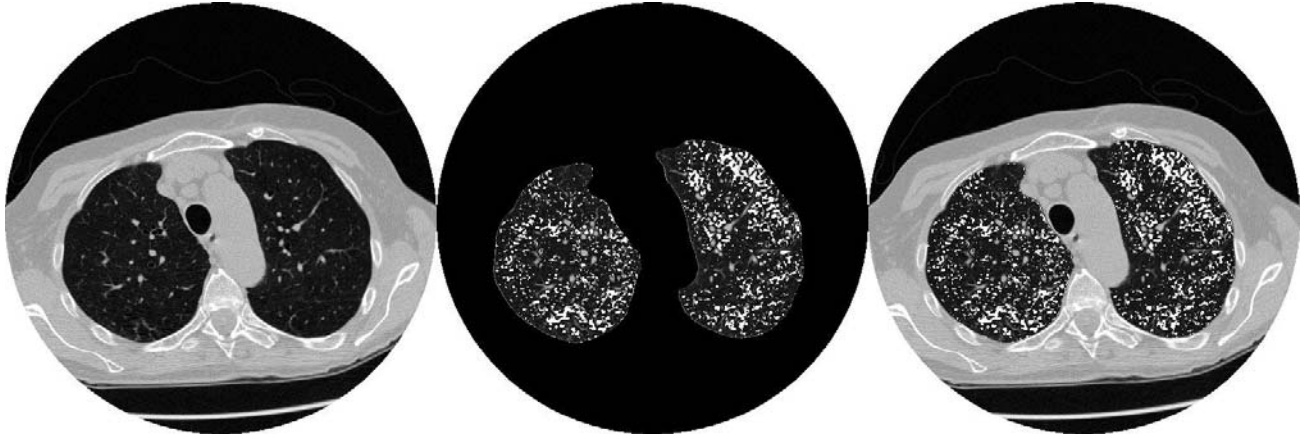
Sample emphysema index computed at -910 HU from a whole lung CT scan. Left: Standard axial CT slice. Center: White regions extracted denoting emphysematous regions defined by attenuation area of less than -910 HU. Right: Overlap of emphysema regions on original scan.
